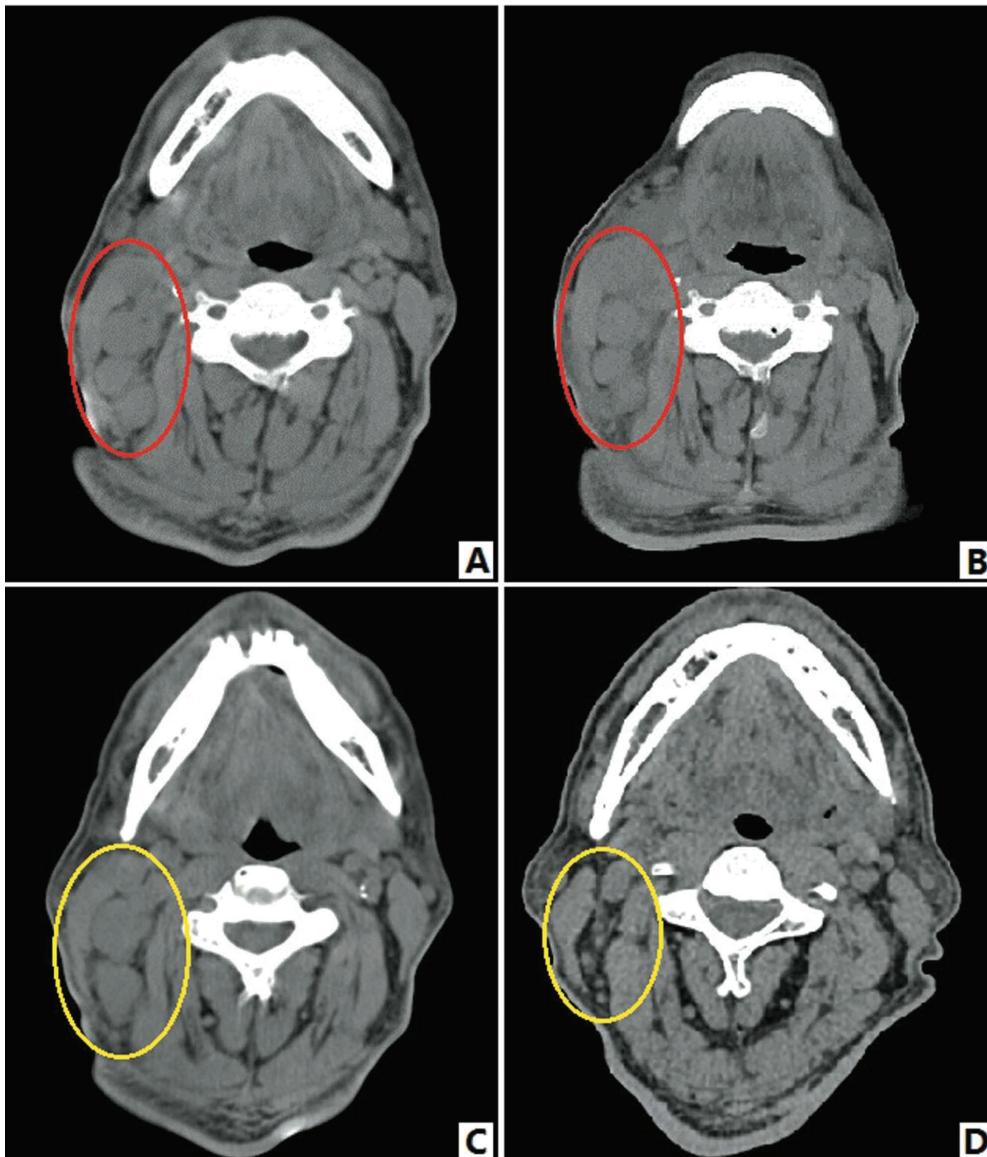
Changes in the lymph nodes in the 2 chimeric antigen receptor (CAR)-T 19 cell therapies. A. Neck computed tomography (CT) before the first therapy; B. Enlargement of cervical lymph node after the 1st therapy; C. The cervical lymph node increased in size again after ibrutinib therapy; D. The size of the cervical lymph node returned to normal after the 2nd CAR-T 19 cell therapy
